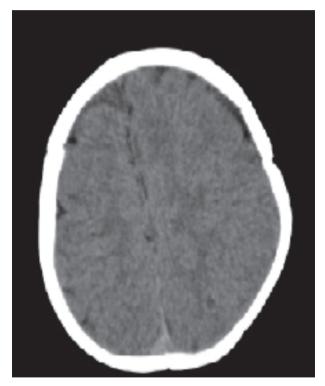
Follow-up computed tomography in 1 year shows no residual or recurred lesions. Bony defect is not seen in operation site
